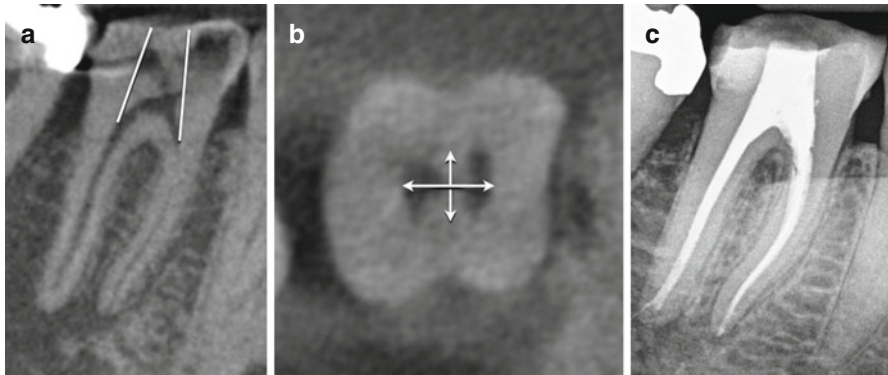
Treatment plan for a conservative access design of a mandibular right first molar based on the exact pulp chamber morphology as determined via the CBCT scan. The sagittal CBCT slice demonstrates the planned minimum mesial/distal outline form (*white lines*) (a), and the axial CBCT slice captured at the level of the canal orifices demonstrates the planned mesial, distal, buccal, and lingual access extensions (b). The post-endodontic radiograph demonstrates a minimal access preparation and appropriate root canal system management (c)
